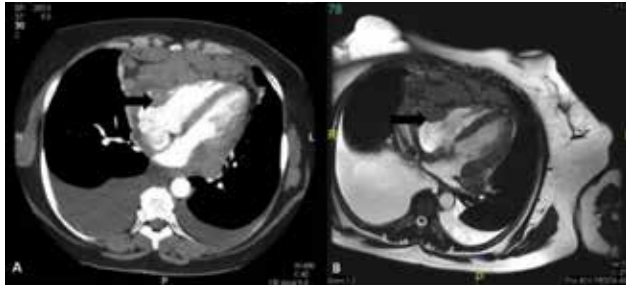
Thorax CT at left and cardiac MRI at the right side. Both revealed lobulated conglomerate mass around heart, invading into pericardium and right atrium (shown with black arrows). Bilateral pleural effusion was also seen.
